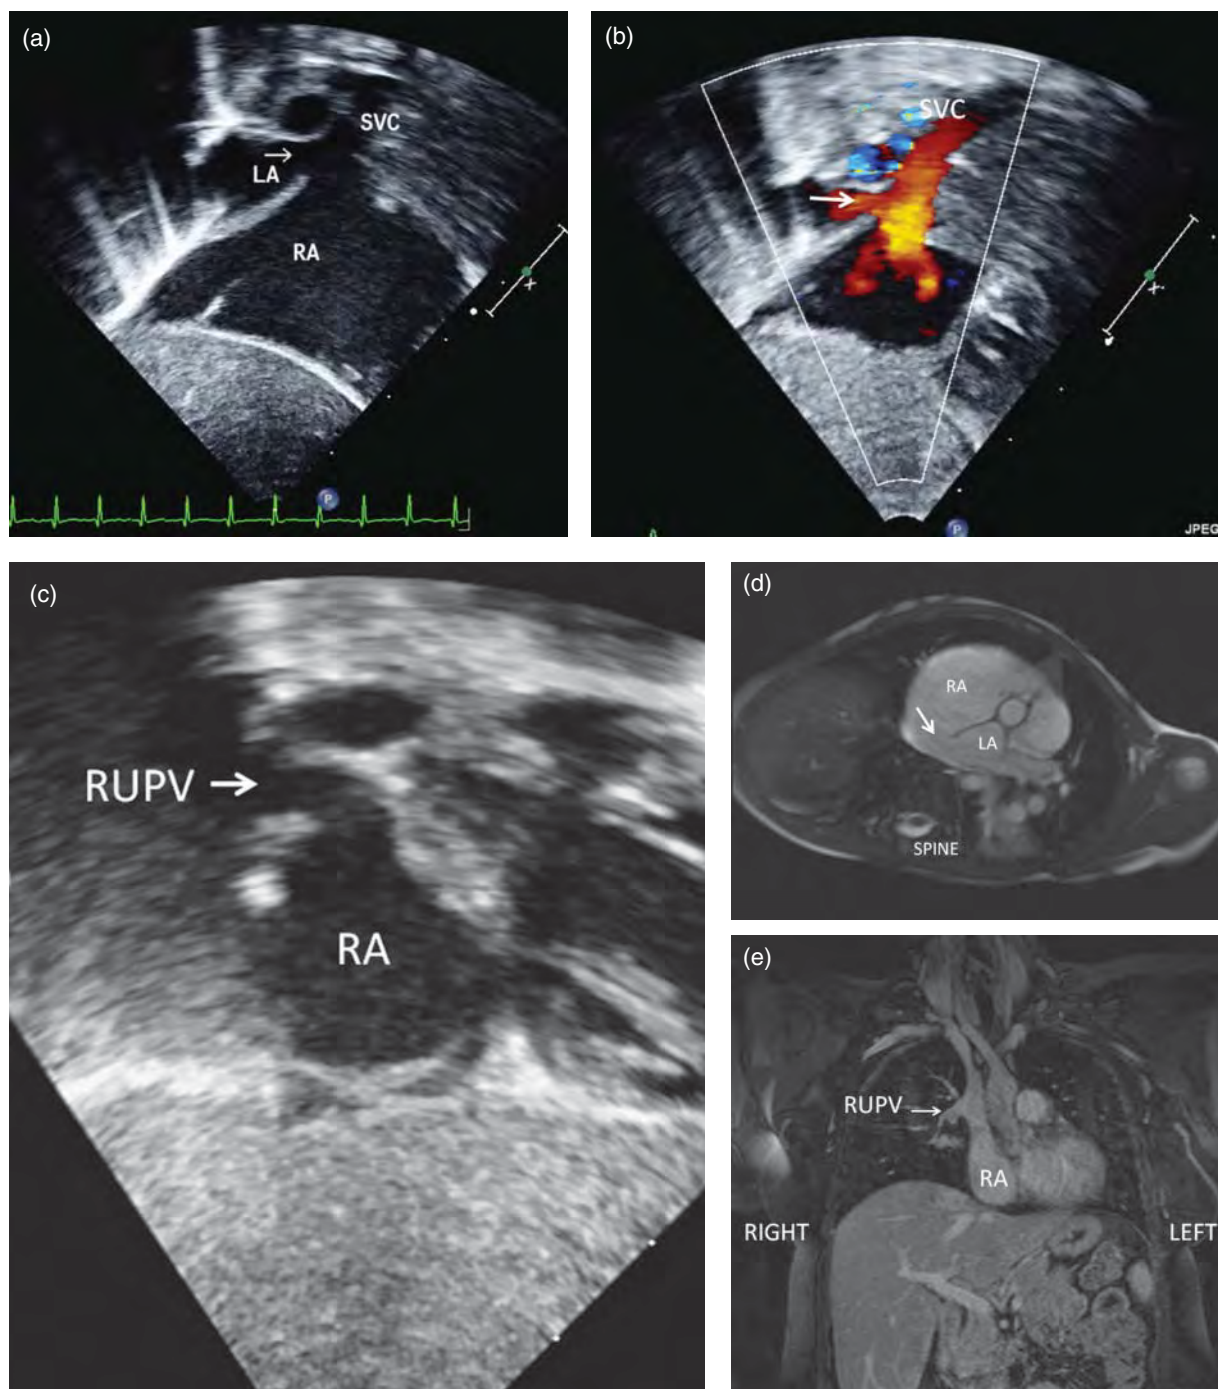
Sinus venosus ASD. (a) Subcostal echo image demonstrating a superior sinus venosus ASD (arrow) just beneath the superior vena cava (SVC). (b) Color flow mapping confirms the presence of the atrial level shunt (arrow) which courses from right atrium (RA) to left atrium (LA). (c) Further two-dimensional image, sweeping from the SVC inferiorly, the anomalous connection of the right upper pulmonary vein (RUPV) into the SVC at the RA–SVC junction. (d) Magnetic resonance angiography in an axial view through the chest confirms the presence of a superior and posterior sinus venosus ASD (arrow). (e) Anomalous RUPV can be quite difficult to see consistently by echocardiography but their connection with the SVC can be confirmed by MRI as shown in this coronal view through the chest.
